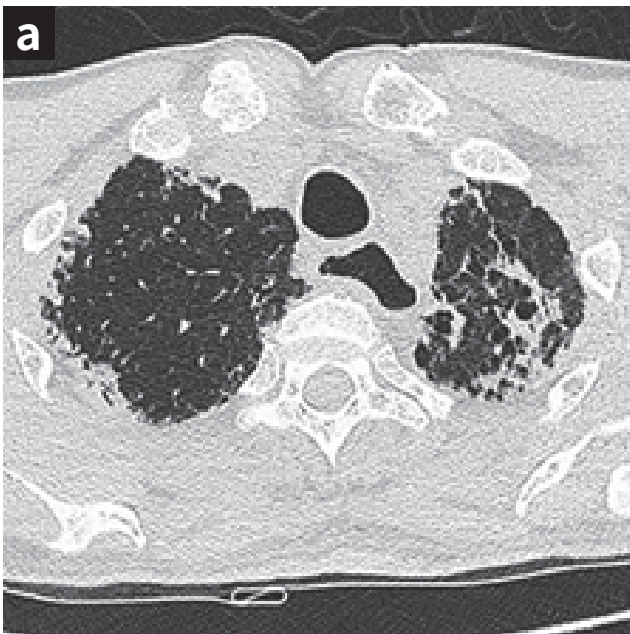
2d: HRCT findings
